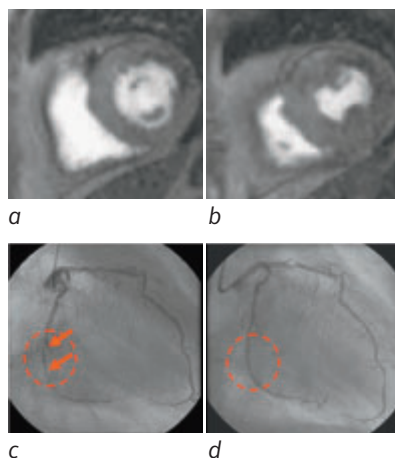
76 year old female with previous PTCS and stenting on LAD, now suffering symptoms of frequent chest pain. a) and b) stress perfusion images more basal and apical respectively, c) X-ray angiogram showing multiple stenoses in LCX, d) angiogram following stenting of LCX.
